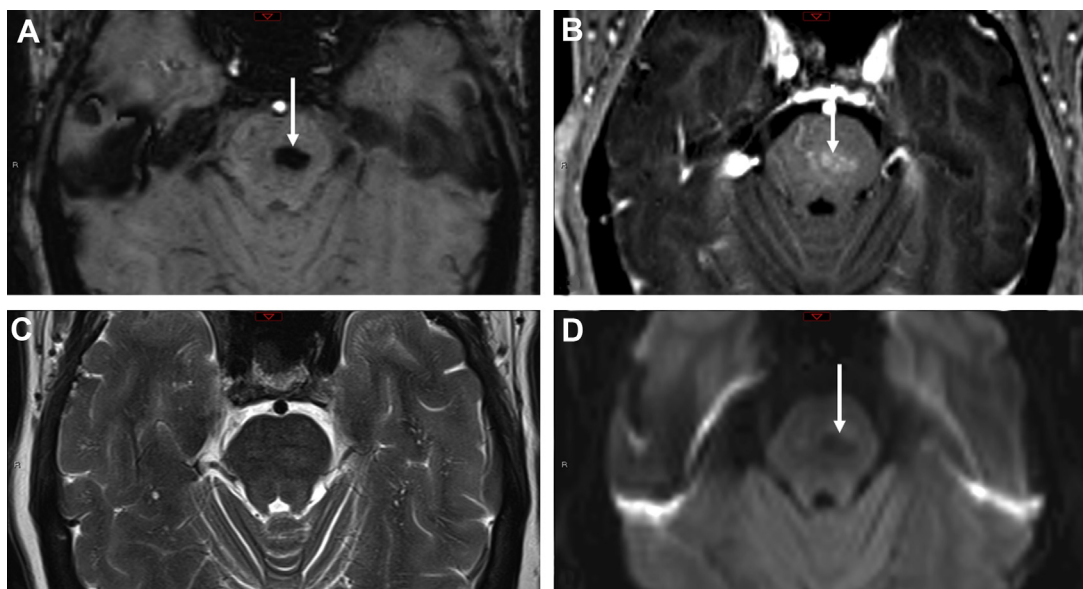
Capillary telangiectasia. Axial SWI (A), axial postcontrast T1-weighted (B), axial T2-weighted (C), and axial DWI (D) MR images in a 72-year-old patient with lung carcinoma undergoing cerebral metastasis screening. The central pontine capillary telangiectasia is most conspicuous as a low signal intensity focus on SWI (arrow in A) with corresponding amorphous faint contrast enhancement (arrow in B). The capillary telangiectasia is nearly imperceptible on T2-weighted images and demonstrates T2 blackout effect (low signal intensity) on DWI series (arrow in D).
